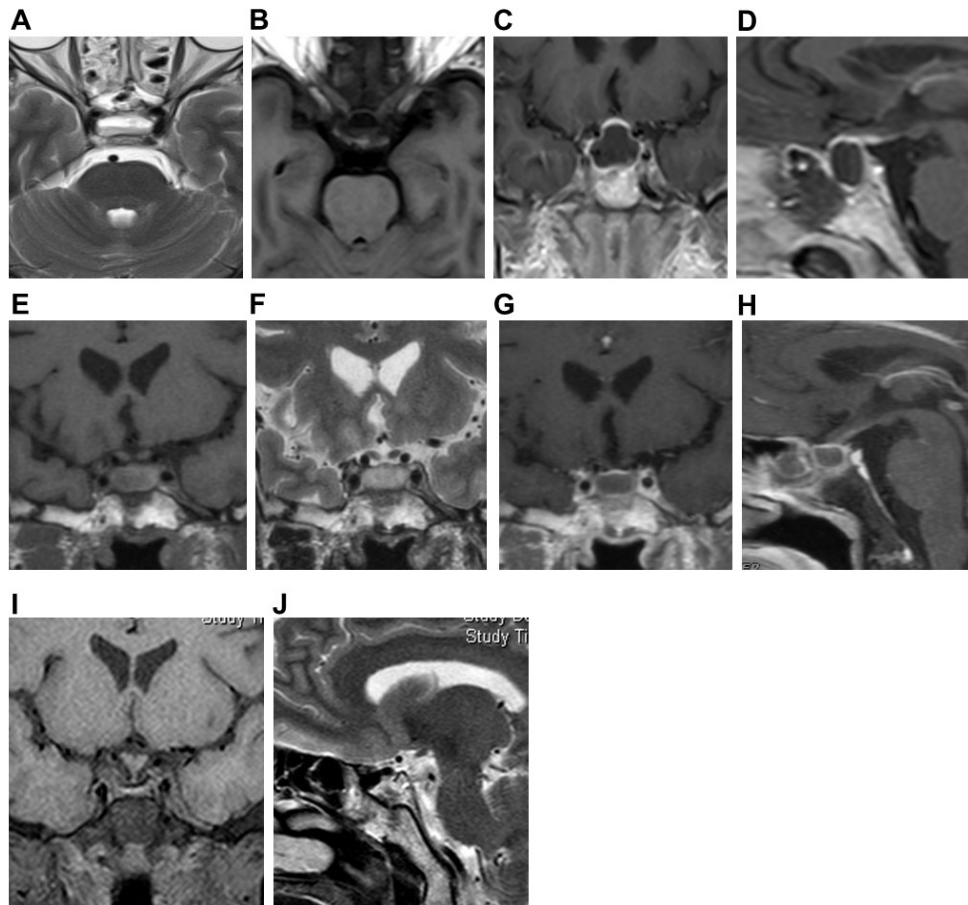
Pituitary gland MRI of Case 3. Preoperative axial (A,B) MRI plain scans showed cystic lesions in the sellar region. T1WI showed uneven and slightly high signal, and T2WI showed a slightly high signal, with a fluid plane inside. Preoperative coronal (C) and sagittal (D) MRI enhanced scan showed ring enhancement of the cyst wall, thickened and enhanced pituitary stalk. Postoperative coronal (E,F) MRI plain scan showed cystic lesions in the sellar. T1WI showed a high signal, T2WI showed a slightly high signal. There was sphenoid Sinus mucosal thickening with effusion. Postoperative coronal (C) and sagittal (D) enhanced MRI scans showed ring enhancement of the capsule wall. Coronal (I) and sagittal (J) MRI plain scans after the second operation showed no recurrence of the pituitary abscess.
